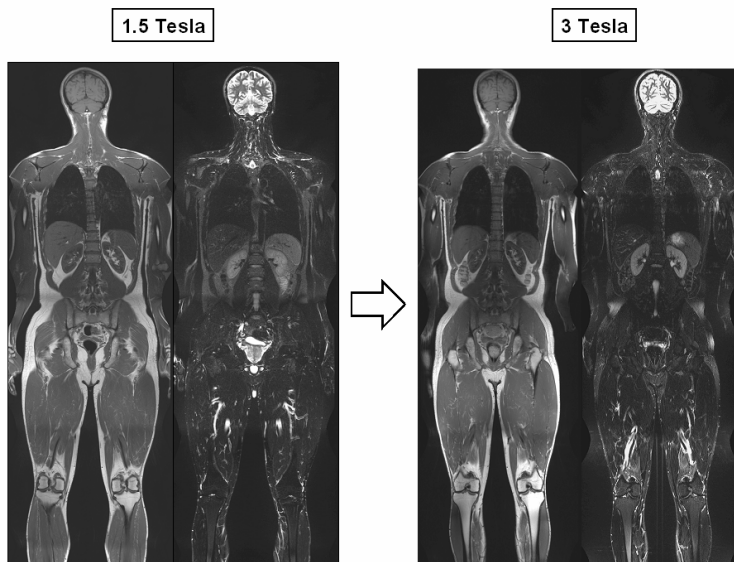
T1-w-TSE and STIR-WB-MRI of 33-year old male on a 1.5 Tesla and 3 Tesla 32-receiver channel scanner with the use of PAT. In WB-STIR at 3 Tesla mild pulsation artefacts are found in the thorax and lower extremities, as well as mild fat suppression inhomogeneity of the lumbar subcutaneous fat tissue.
